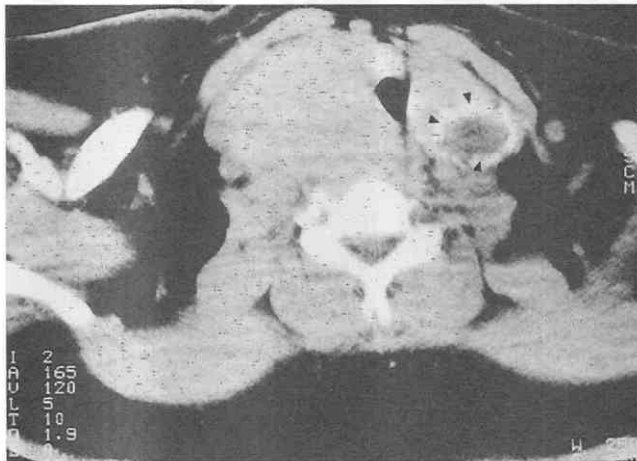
Axial CT scan through the lower neck shows peripheral coarse calcifications (arrowheads) in an adenoma within an enlarged, goitrous thyroid gland. This peripheral calcification may also be thin and eggshell-like.
